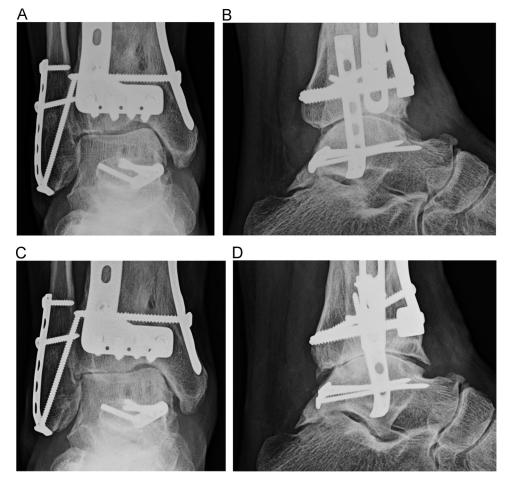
Posttraumatic osteoarthritis. A 21-year-old woman with fractures of the distal tibia, distal fibula, and talus following fall, status-post surgical fixation. Frontal (A) and lateral (B) radiographs of the ankle from follow-up imaging December 2011 relative to January 2014 (C and D) demonstrate a rapid progression of osteoarthritis at the tibiotalar joint.
